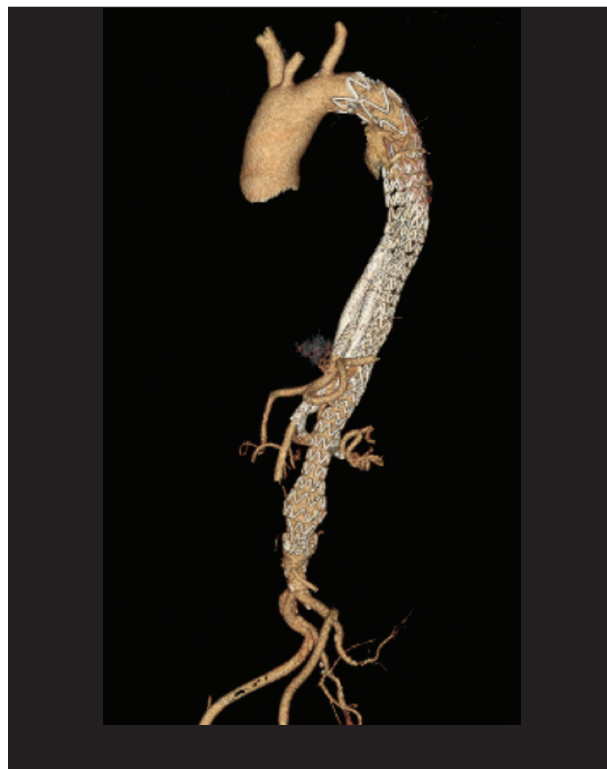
CTA of the type II TAAA at postoperative day 1 after repair with the Medtronic Valiant TAAA thoracoabdominal stent graft system (thoracic bifurcation and visceral manifold components only) as well as other Medtronic components.
